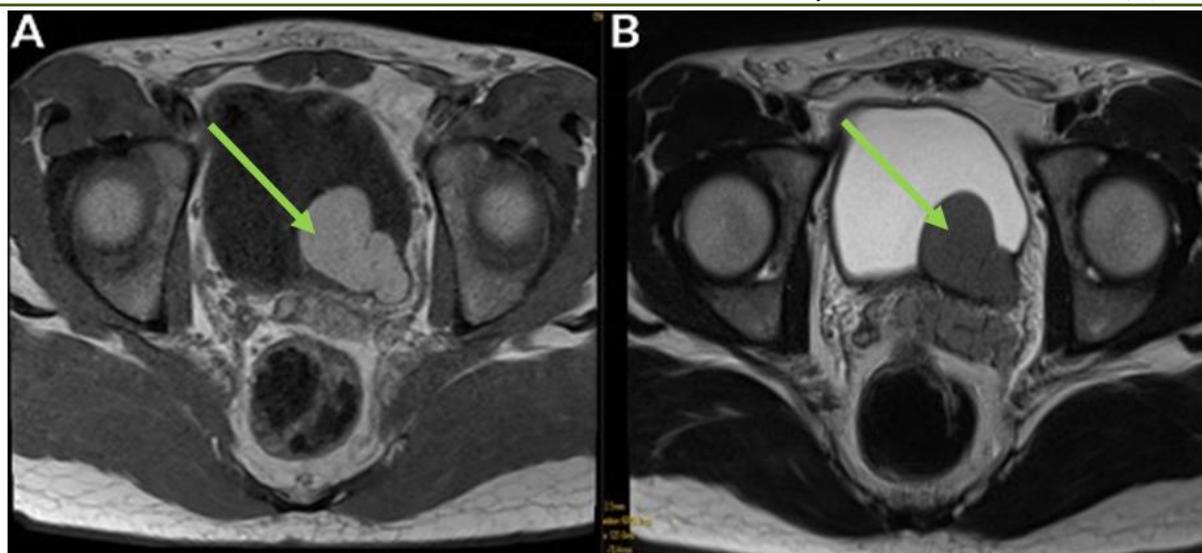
(A) T1 axial MRI cut: cystic formation of the left seminal vesicle which was in hyper signal on T1; (B) T2 axial MRI cut: cystic formation of the seminal vesicle with intermediate signal on T2
